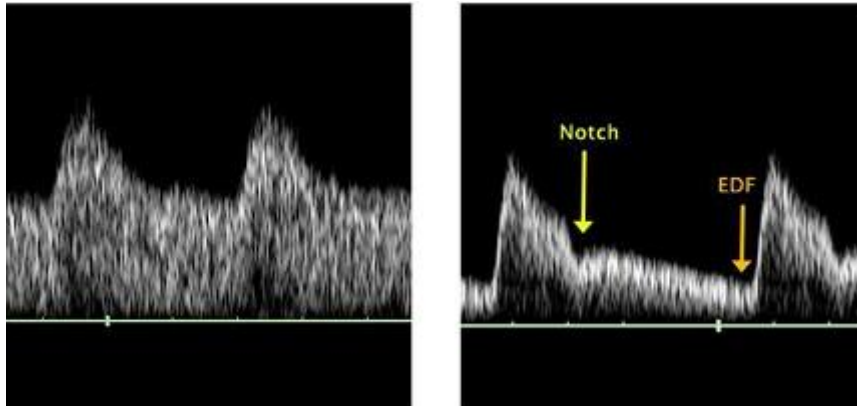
Uterine artery Doppler studies at week 28 in a woman with a normal pregnancy (left) and in women with pre-eclampsia
